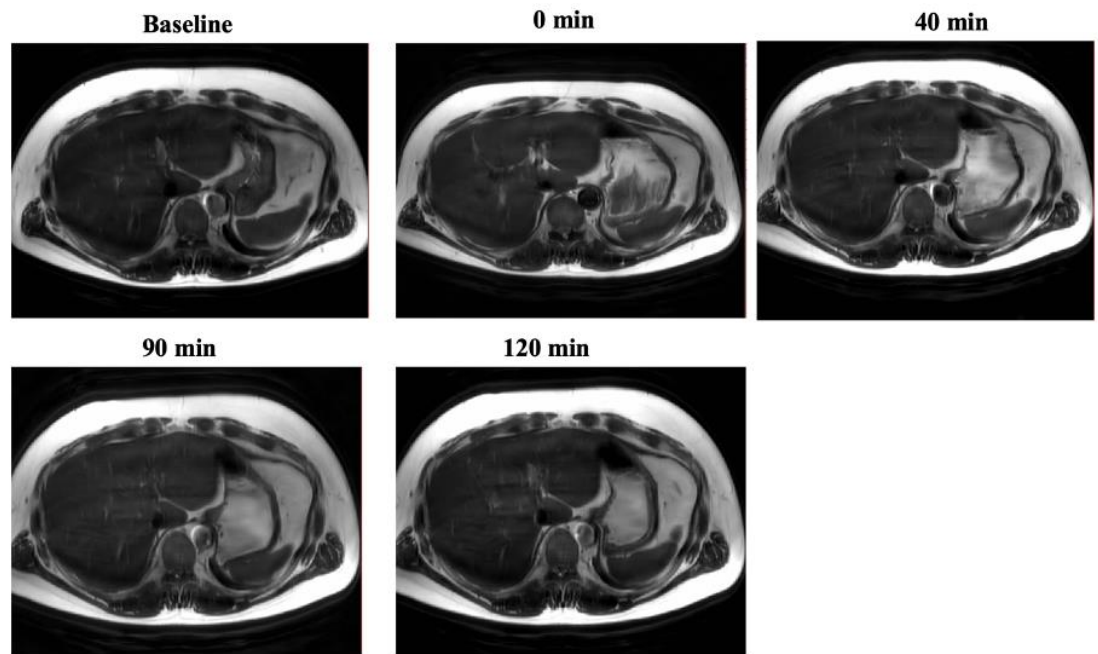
Examples of MRI images of a participant with obesity showing the stomach at fasting/baseline and at different time points following the consumption of the high-fat and high-carbohydrate drinks.
